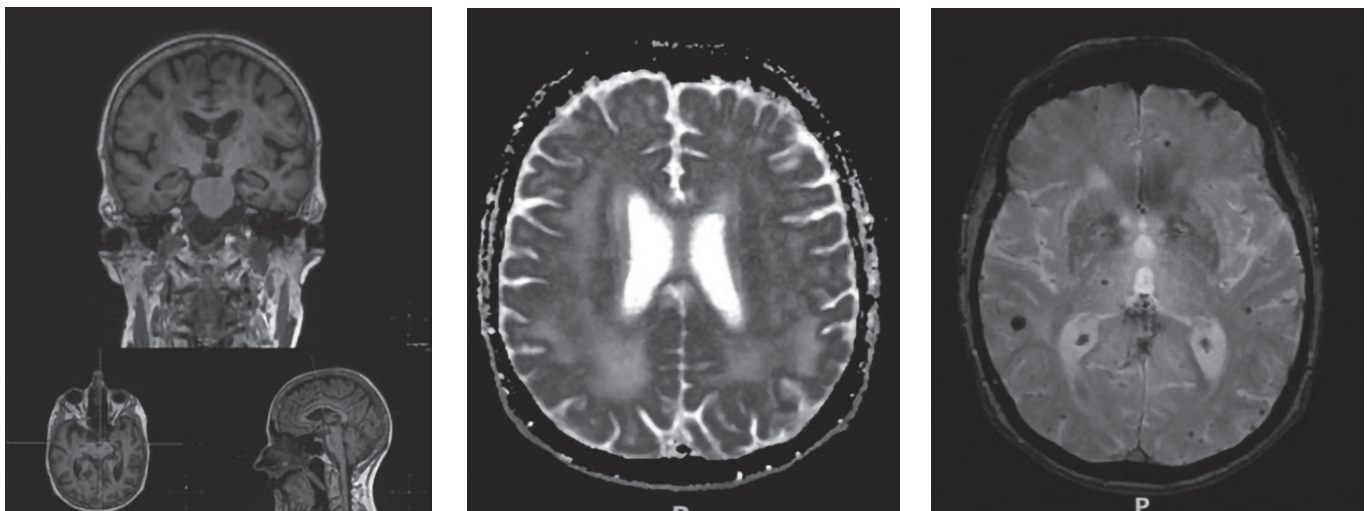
Magnetic Resonance Imaging (MRI) of the brain
